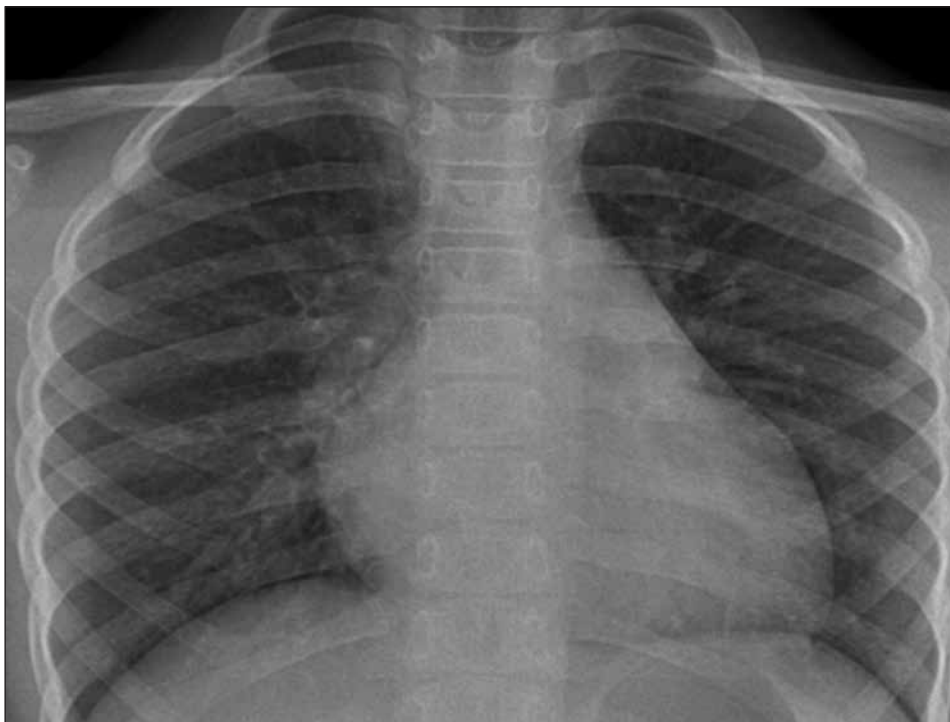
Chest X-ray of a child with large ASD and hemodynamically significant left-to-right shunt.
